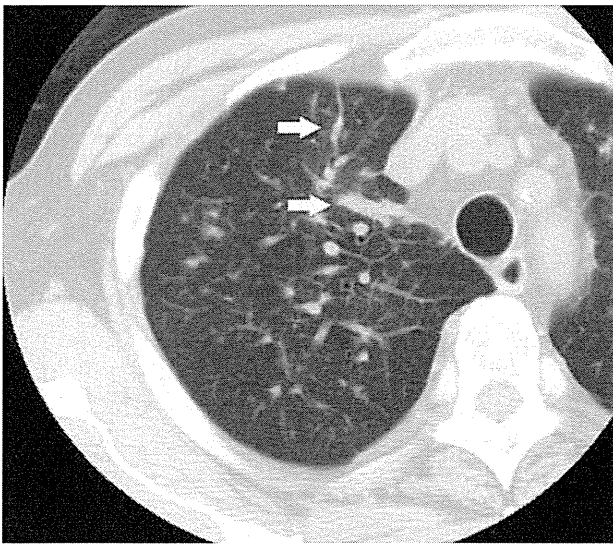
Irregular pulmonary vein dilation (case 3): chest CT scan taken 2 weeks after the last admission shows irregular pulmonary vein dilation (arrows) and increasing small nodules.
